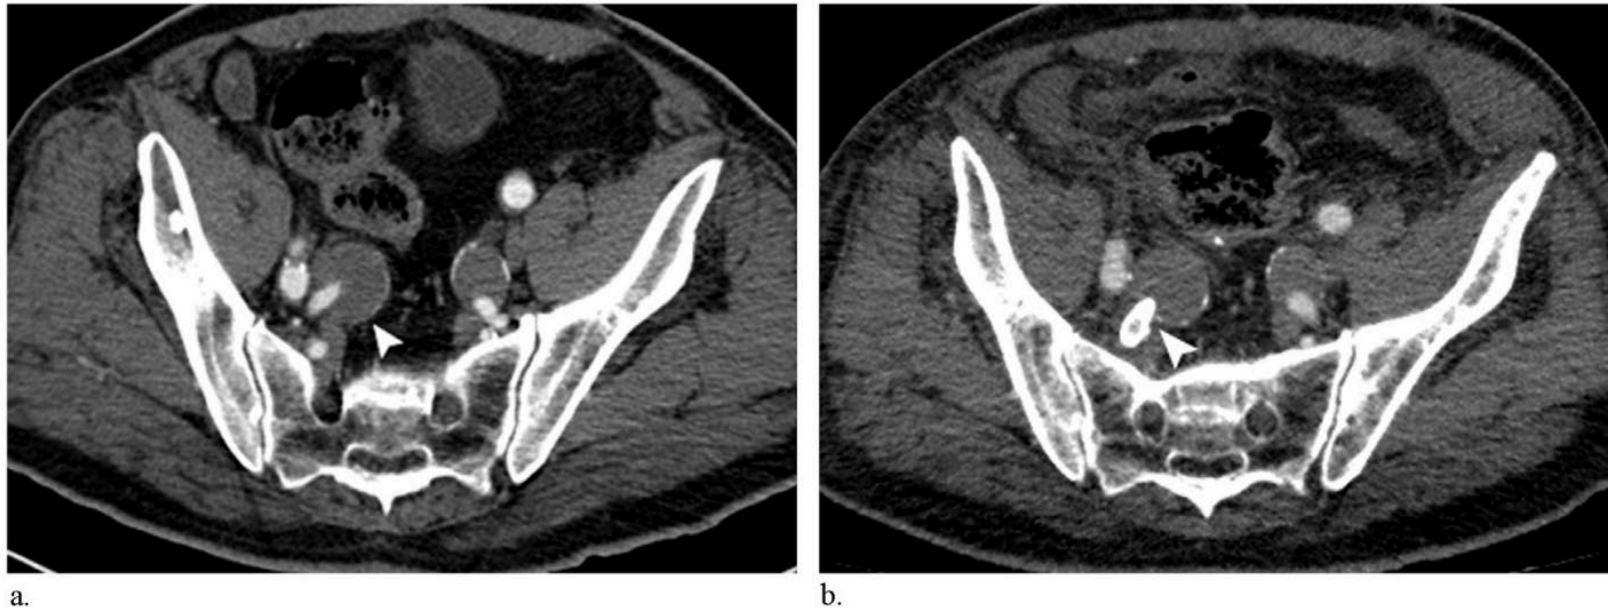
(a) Axial CT angiogram in patient 2 before intervention. Arrowhead indicates a right IIA aneurysm. (b) Axial CT angiogram in patient 2 at 1 year after the procedure. Arrowhead indicates the excluded right IIA aneurysm with a patent stent graft.
